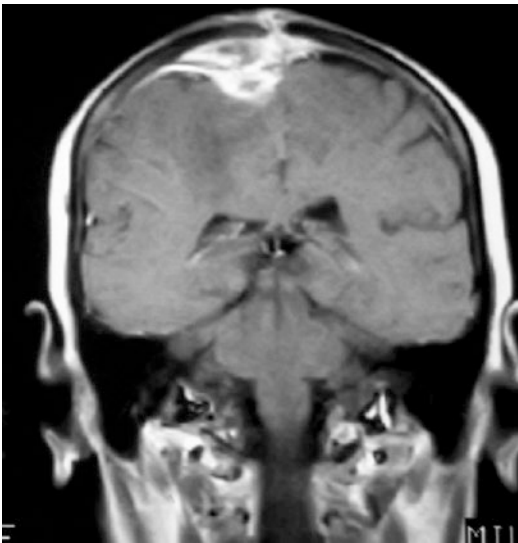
TB epidural and subdural empyema. Coronal post-contrast T1-weighted MRI demonstrates dural enhancement and epidural and subdural collections with thick enhancing walls in *right* frontal region. The epidural component extended to the *left* side. Involvement of diploë indicates calvarial involvement
